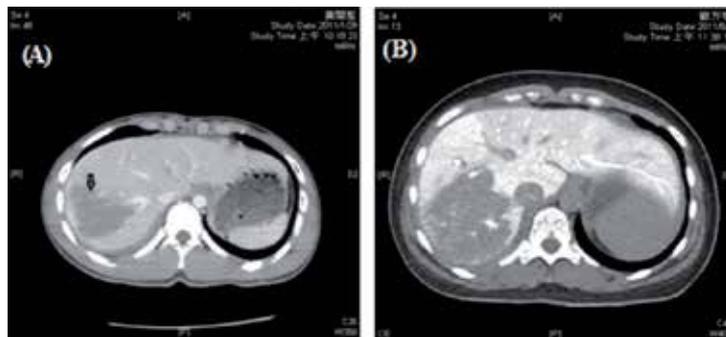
CT scan images of blunt abdominal trauma patients. (A) CT scan of liver showing intraparenchymal hematoma in segment VI. (B) CT scan of liver showing intraparenchymal hematoma in segment VI and extending to segment VII and V.
